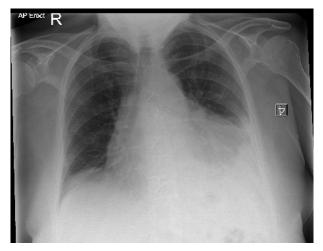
Chest radiograph showing cardiomegaly on initial admission.
